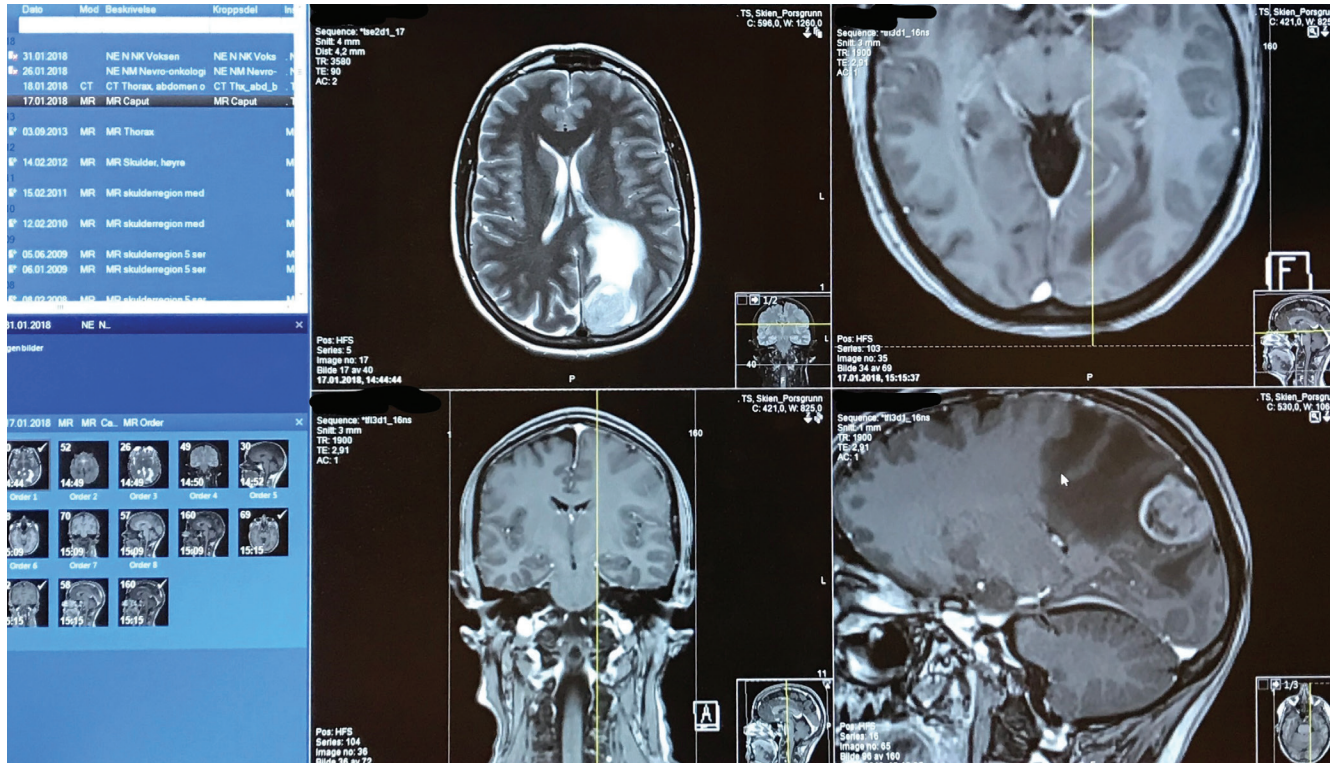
Gulliksen, 17 January 2018. Screenshot of MR image of my tumour.
